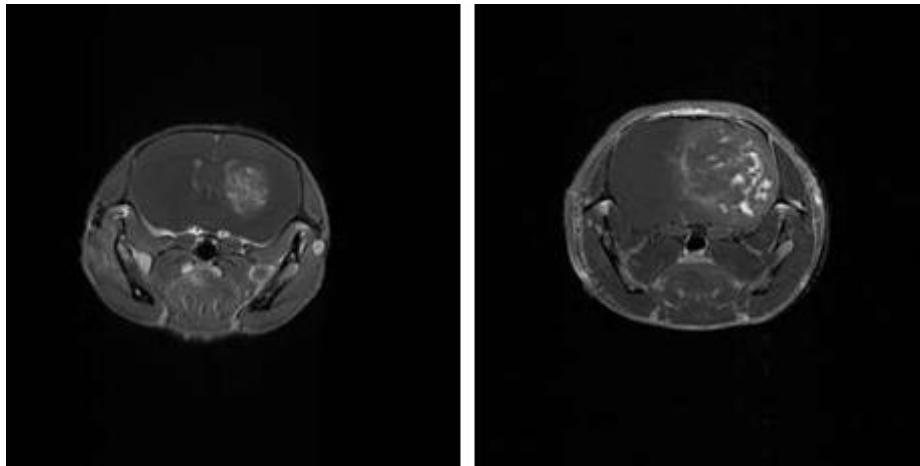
T2-weighted MRI-scans without contrast medium on day 29 p.o., showing a treated pLXSN-tumor on the left and an untreated pLXSN-tumor on the right. Antiangiogenic treatment caused a significant reduction in tumor volume in treated pLXSN-tumors compared to the untreated pLXSN-tumors.
